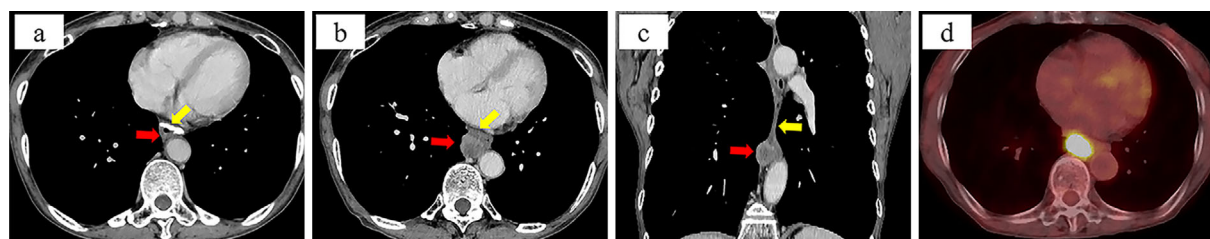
The initial size of lymph-node swelling was 4 mm in size (a), but it gradually increased to 23 mm over 8 years (b, c). An accumulation of ^{18}F -fluorodeoxyglucose was observed at the same lesion by ^{18}F -fluorodeoxyglucose positron emission tomography-computed tomography (d). Red arrows: tumor, Yellow arrows: esophagus.
